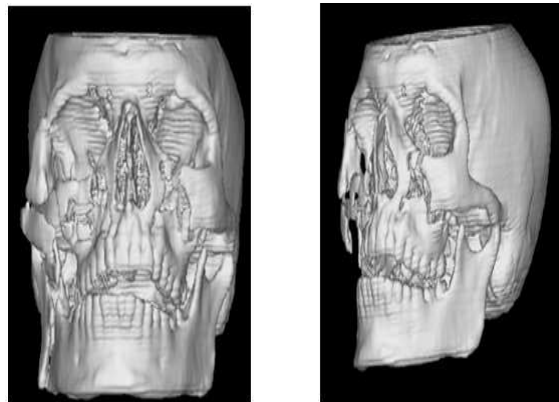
Radiographs (Waters view, SMV view and OPG) and 3D CT images of patient 2 showing comminuted fracture of right zygomatic maxillary complex and fracture right body of mandible. Degree of comminution, extent of fracture & displacement are much better appreciated on 3D CT
